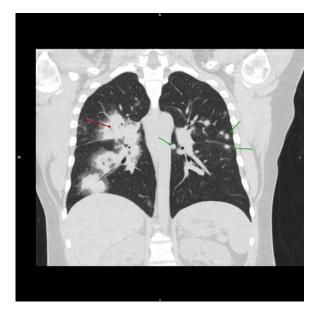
Coronal and axial CT of the chest without contrast demonstrates multiple airspace opacities in a central distribution most within the right upper lobe (red arrow). Sporadic nodular densities where also noted (green arrows). (Color version of figure is available online)
